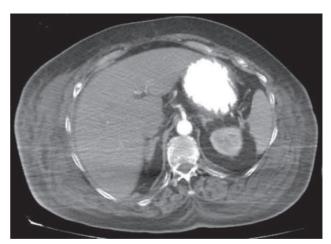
Repeated computed tomography (CT) showed complete remission of gastric dilation and pneumatosis.
